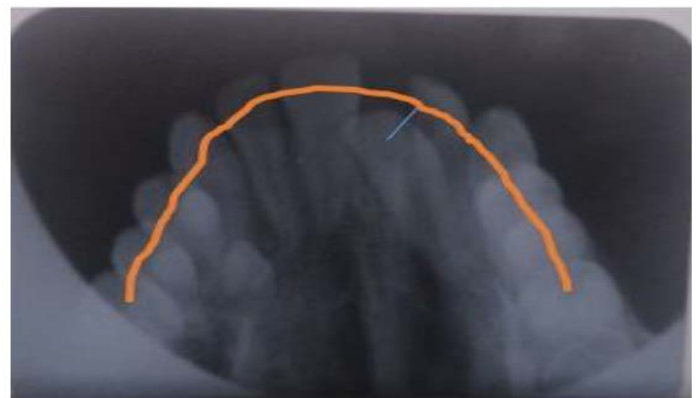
Maxillary occlusal radiograph depicting millimetre rule.
